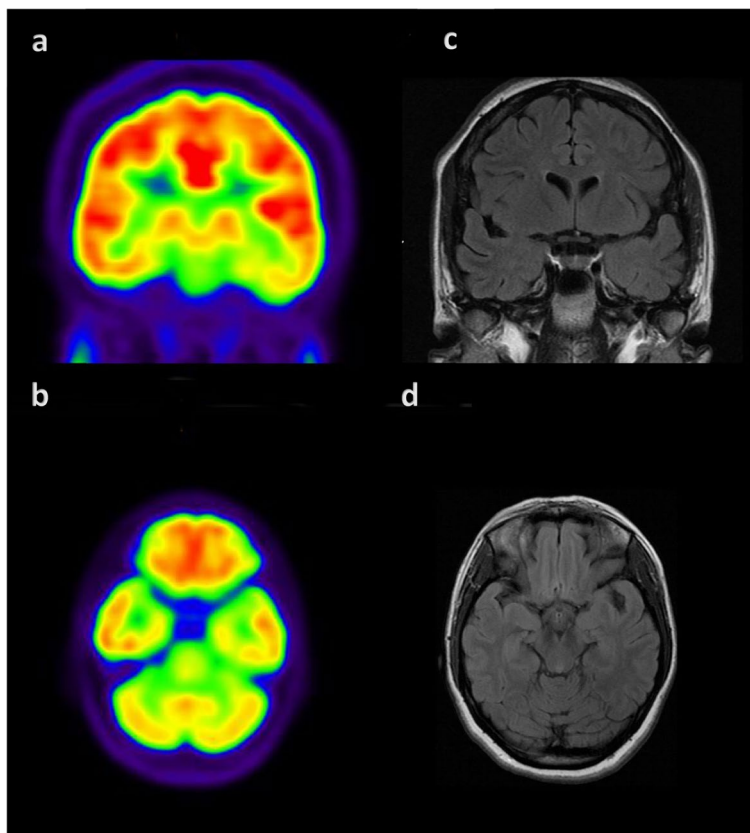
Presurgical phase 1 imaging results. a. A coronal slice of brain FDG-PET/CT imaging, in high-contrast color scale, demonstrating reduced uptake in the left temporal lobe. b. An axial slice at the level of the temporal pole showing reduced uptake in the left temporal lobe. c, d. Coronal and axial T2 flair images
